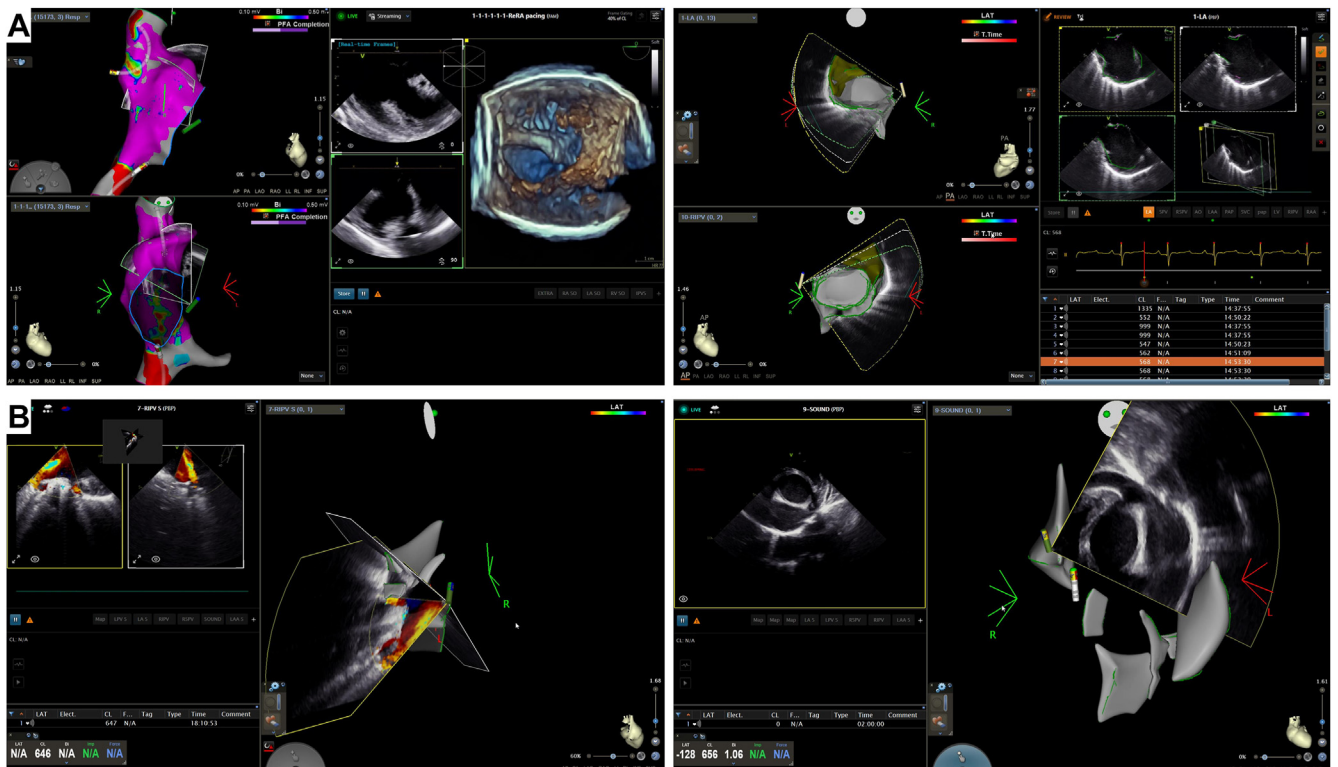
A: Right atrial map with 4-dimensional and biplane ultrasound image of the crista terminalis. B: Color Doppler flow of the left atrial veins (left) and ablation catheter tracking (right).
